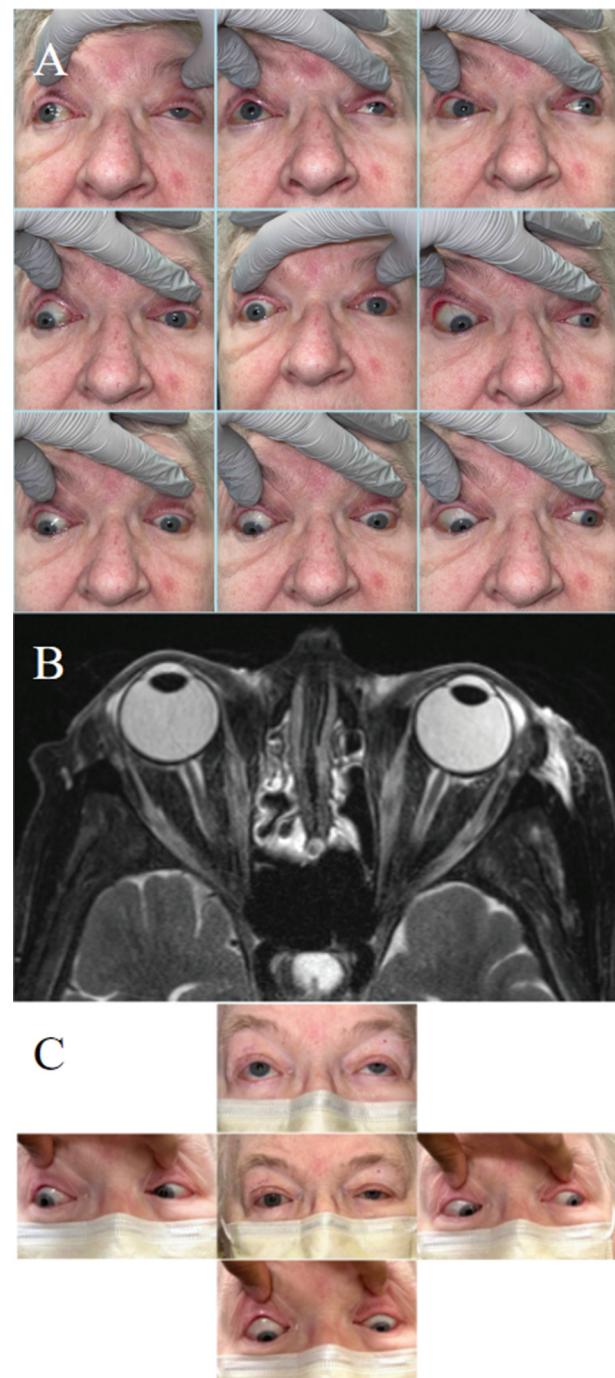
External photographs at presentation (A) show bilateral limitations in all directions of gaze. Axial T2-weighted MRI orbits with contrast (B) shows patchy hyperintensity and edema within the bilateral extraocular muscles. External photographs at 11 week follow up (C) show improvement in gazes.
